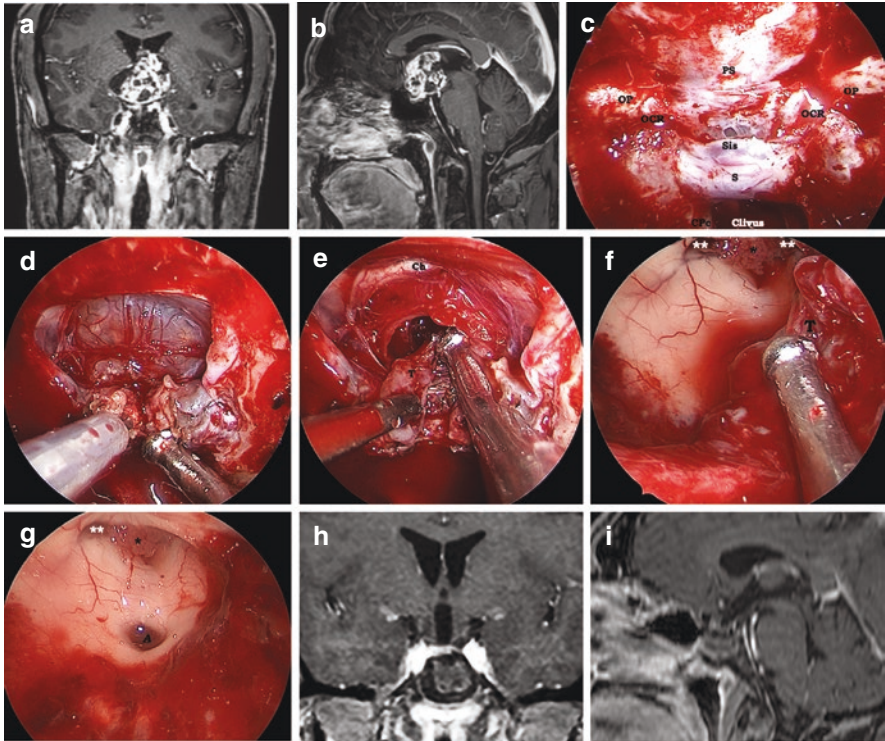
Resection of intraventricular craniopharyngioma through an endoscopic trans-sphenoidal approach: Preoperative coronal (a) and sagittal (b) MRI scan showing an intraventricular craniopharyngioma. Bone opening (c) defining the transtuberculum-transplanum approach; after the opening of the dura, internal debulking of the tumor (d) is achieved with the aid of an ultrasonic surgical aspirator (CUSA). A cleavage plane ensures the dissection of the tumor from the optic chiasm (e) and the integrity of adjacent third ventricle wall (f). View into third ventricle demonstrating removal of tumor and the foramina of Monroe with choroid plexus (g). Third ventricle appears clear of residual tumor. Postoperative T1 coronal (h) and sagittal (i) MRI scan imaging performed at 6 months after surgery revealing the gross total resection of the tumor and the residual amount of autologous fat and the pedicled nasoseptal flap used to reconstruct the osteodural breach according to the 3F technique. *S* sella turcica, *Sis* superior intercavernous sinus, *OP* optic protuberance, *OCR* optic carotid recess, *CPc* paraclival internal carotid artery, *PS* planum sphenoidale, *Ch* optic chiasm, *T* tumor, * choroid plexus,  Monro foramen, *A* aqueduct
